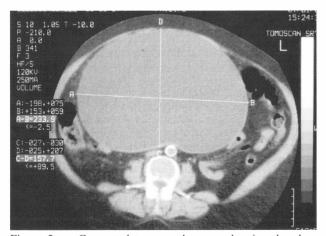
Computed tomography scan showing the clear margins and thin wall of the mass, which subsequently was demonstrated to be a voluminous twisted right paraovarian cyst.
